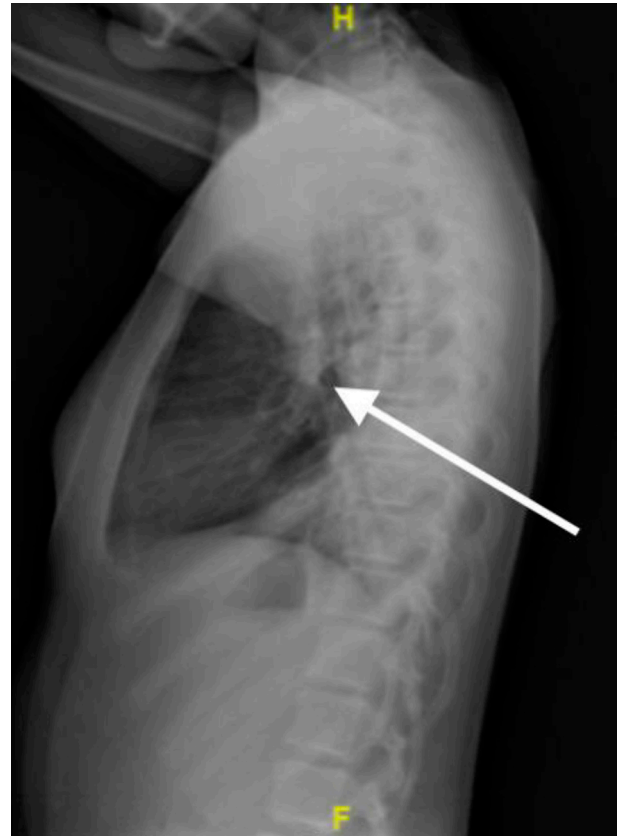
Chest X-ray, lateral view on third presentation to emergency department showing signs of pneumonia with areas of consolidation.
